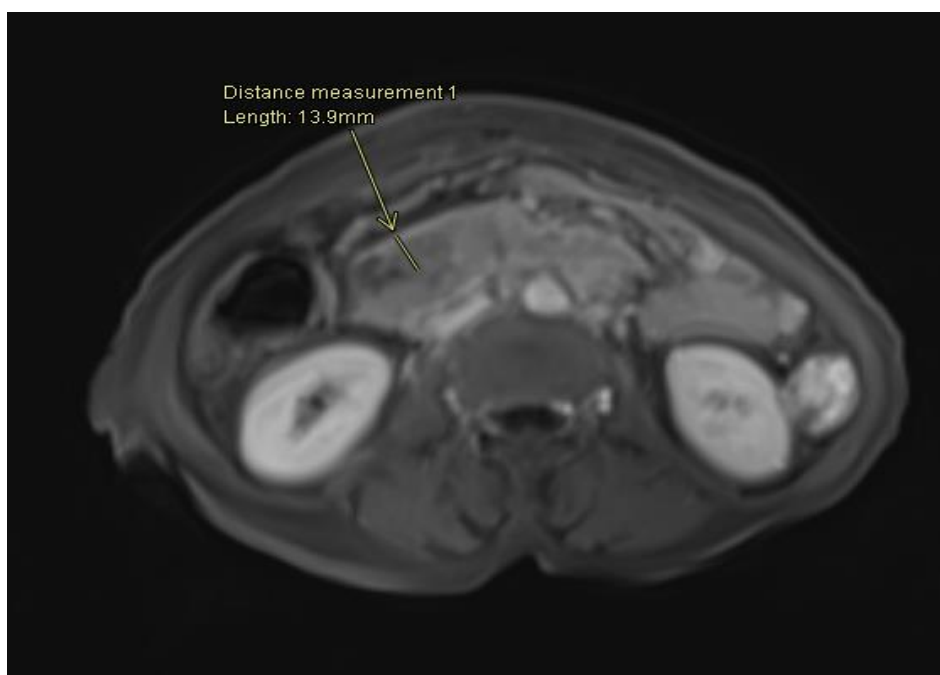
MRI abdomen after resection showing marked, diffuse wall thickening involving the duodenum, measuring up to 1.4 cm in thickness.
